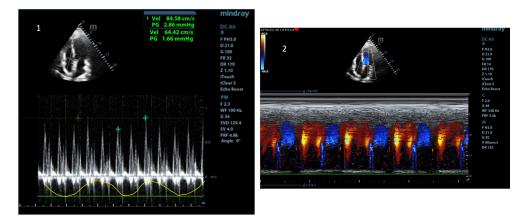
c.2. Left (1): respiratory variations of the E-wave of transmitral flow (PW Doppler, apical 4-chambers view); Right (2): increased transmitral diastolic flow propagation velocity (color M-mode, apical 4-chambers view)
